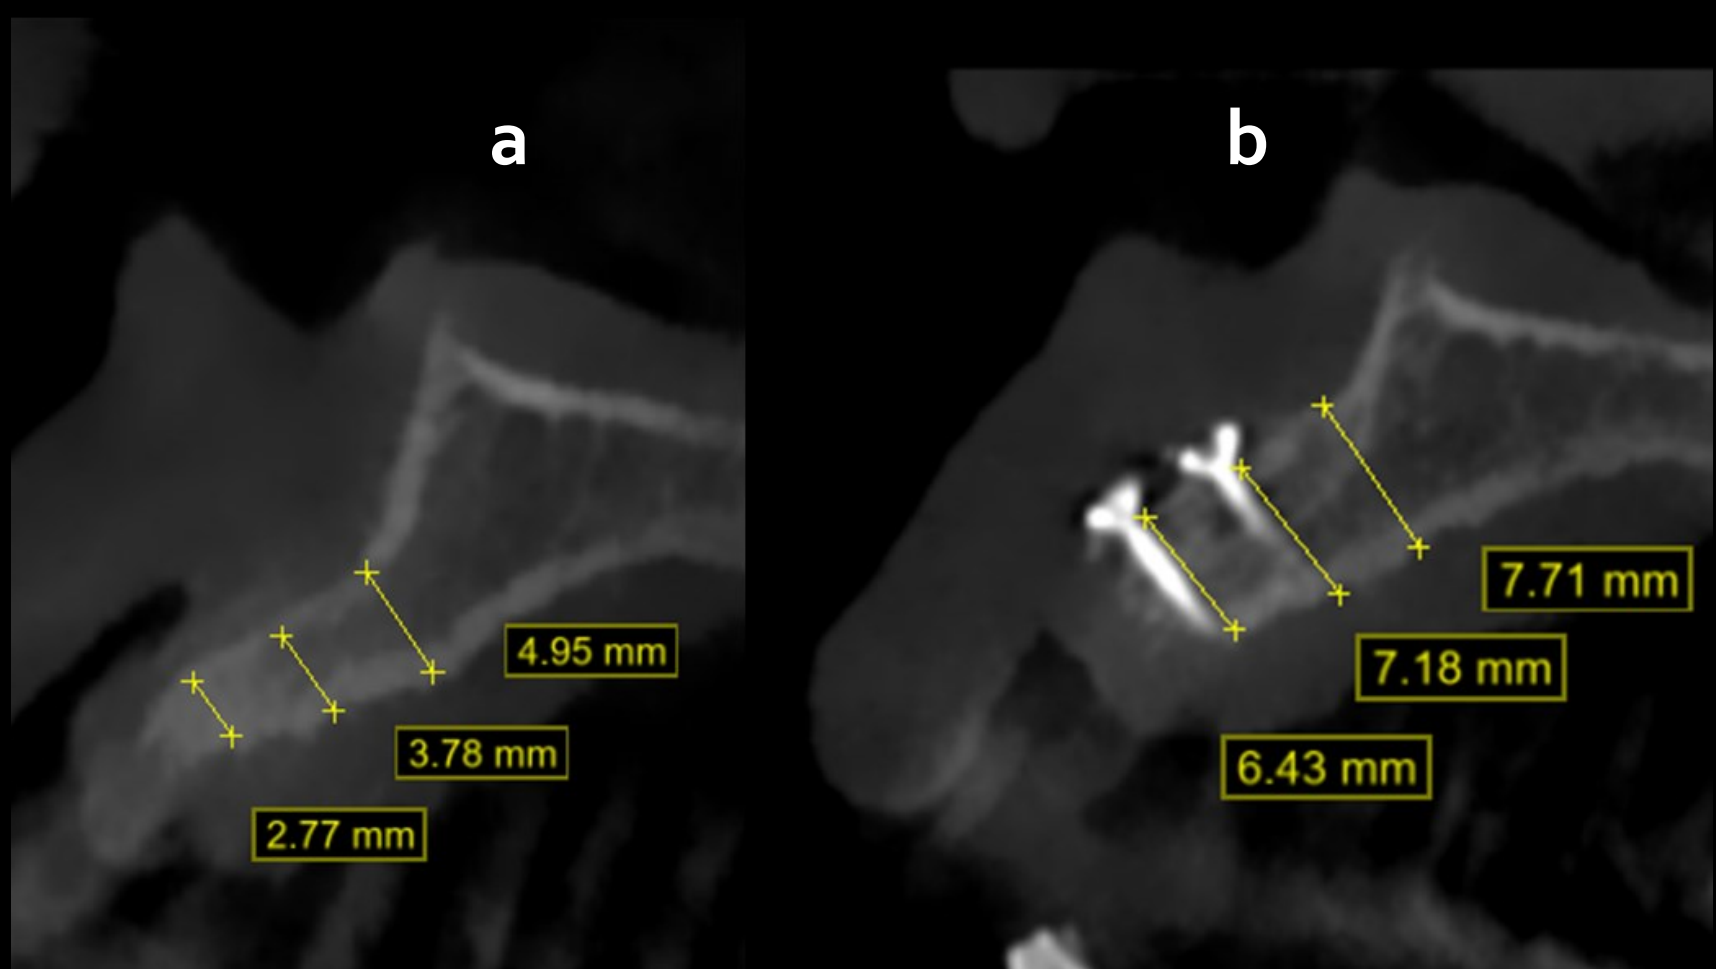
a) Pre surgery CBCT b) Post surgery CBCT.
